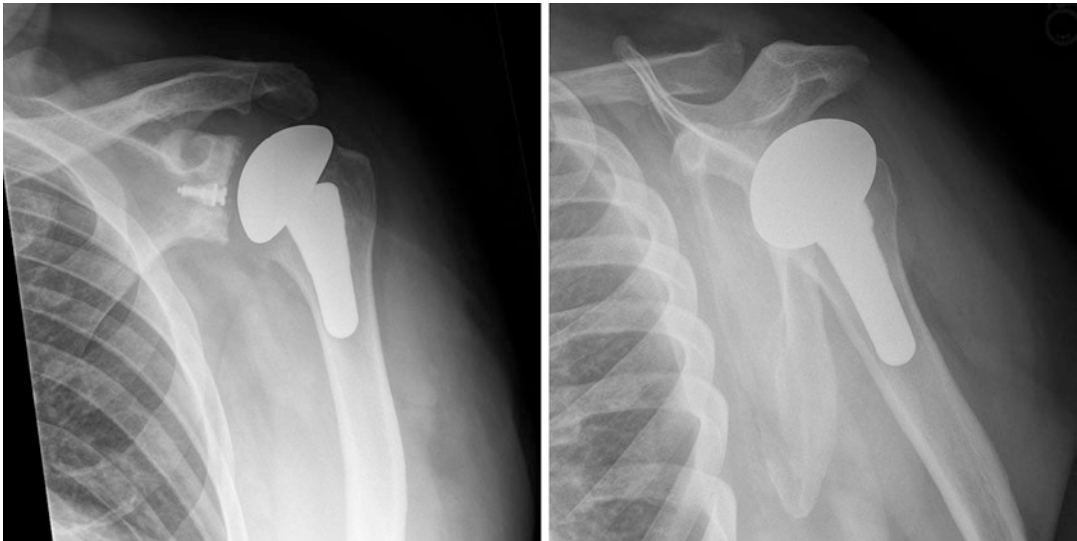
Postoperative radiographs of the left shoulder
